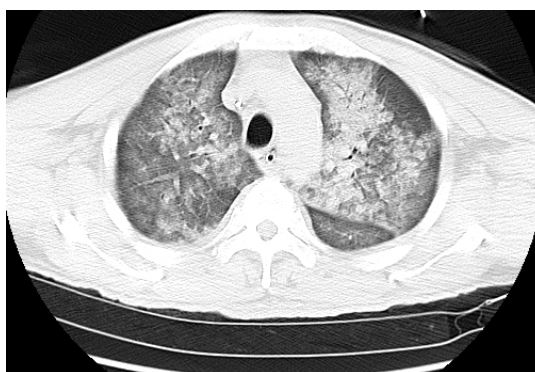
Pulmonary CT at admission microbiological findings.
